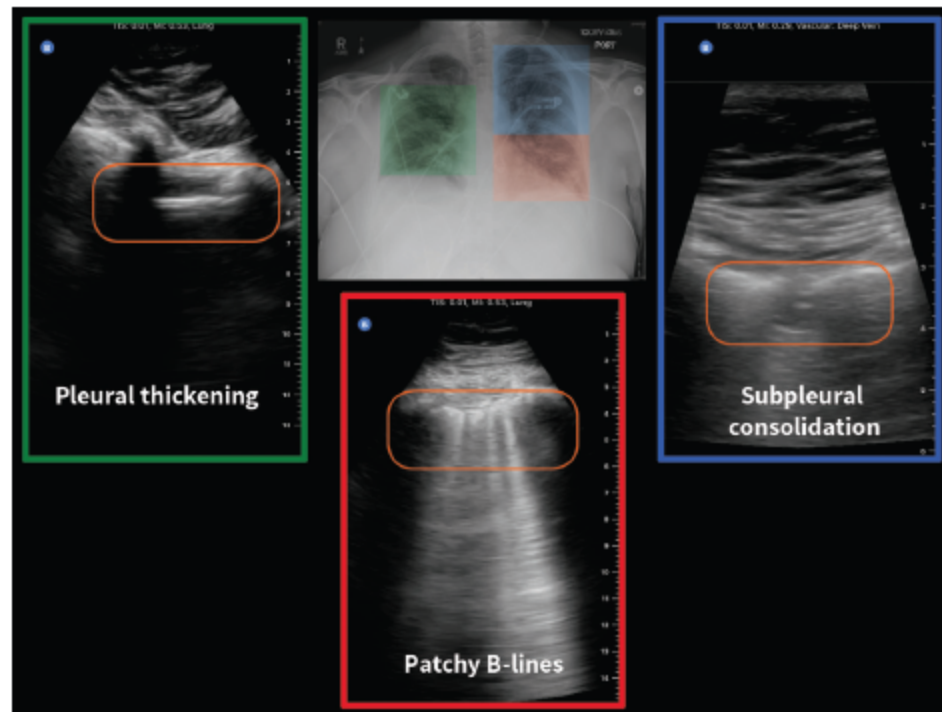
Lung ultrasound of a 64-year-old female health care worker with no travel history, on day 10 after symptom onset. The lung point-of-care ultrasound shows pleural thickening (right lung: green box); subpleural consolidation, also known as “skip lesion” (left upper lung: blue box); and multifocal B-lines (left lung: red box). The chest radiograph shows bilateral infiltrates.
